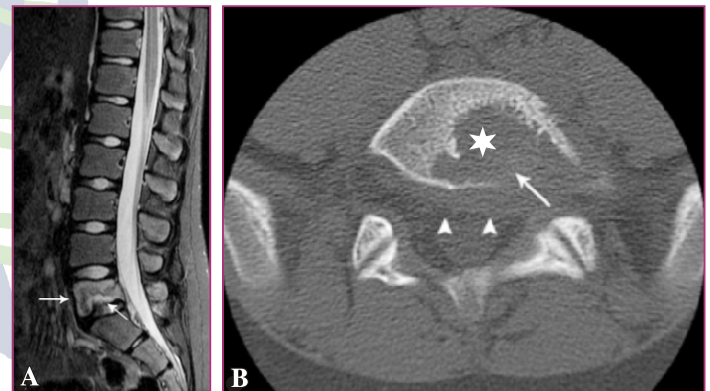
A : Langerhans Cell Histiocytosis. (A) Sagittal fluid-sensitive MR image of the lumbar spine in a 12 year old boy with back pain demonstrates edema within the L5 vertebral body (thick arrow) with bone destruction of the inferior aspect of the vertebra (thin arrow).
